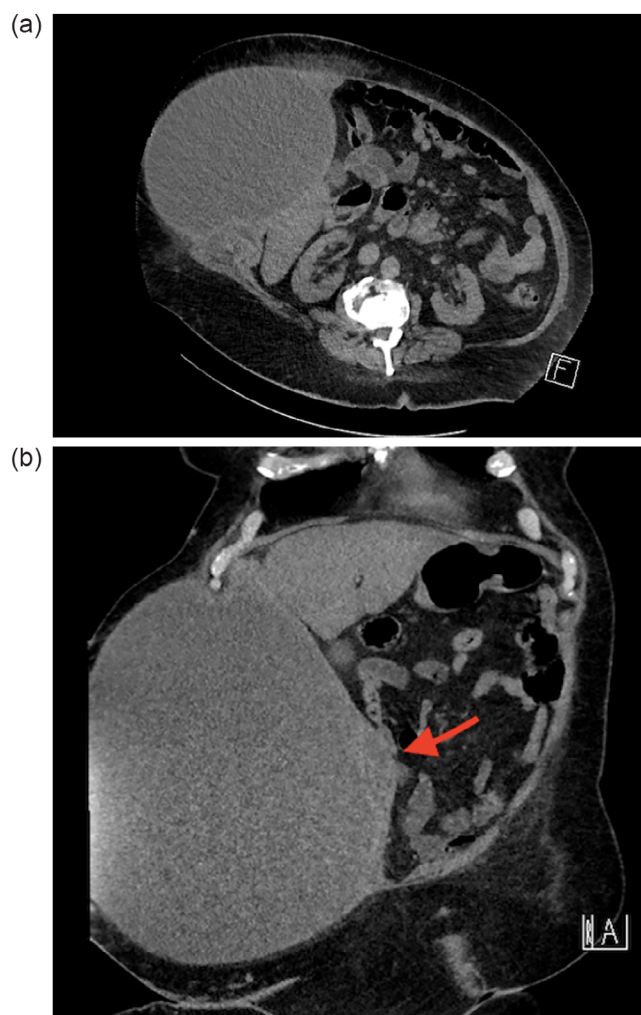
Computed tomography scan in axial (a) and coronal (b) slices showing massive abdominal wall collection (total drained volume 11 L).
